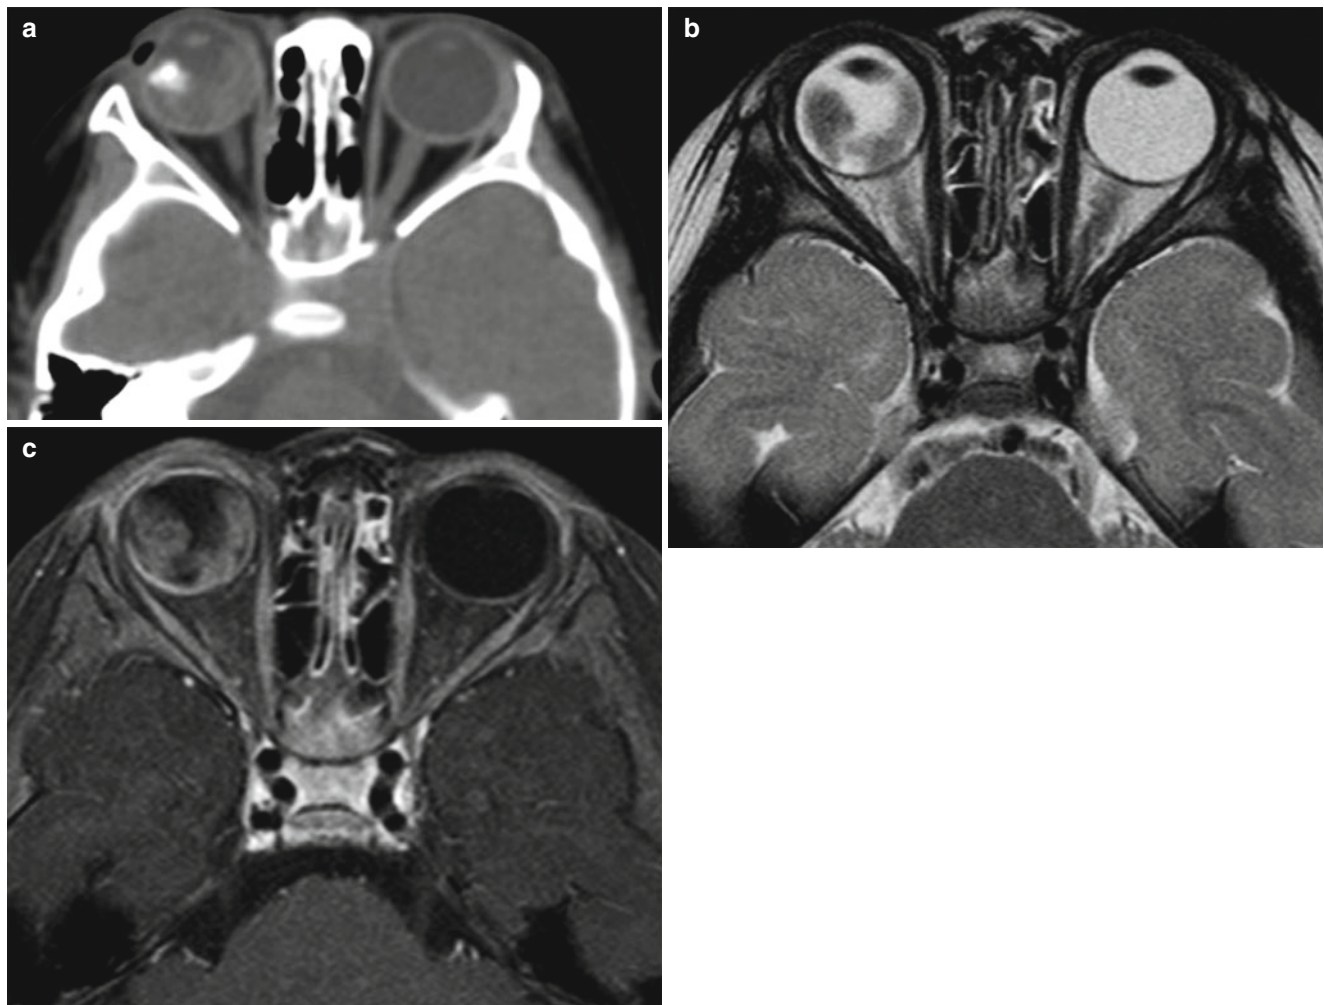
Retinoblastoma in a 2-year-old girl. (a) Nonenhanced CT scan shows a densely calcified solid mass in the right globe. (b) Axial T2-weighted MR image shows a low signal intensity of the mass.
